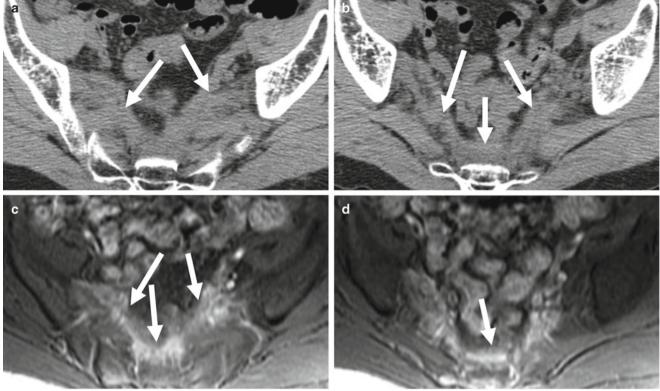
(a, b) Platelike soft tissue density is found along the pelvic wall (arrows). (c, d) On post-contrast MRI the lesion is uniformly enhanced (arrows)
